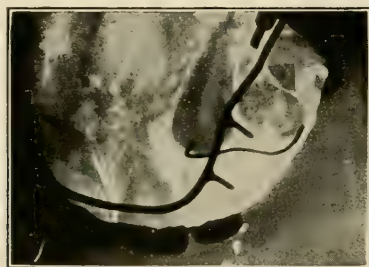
Same as Figs. 150 and 151 after removal of the temporary cuspid. The wire hooked over the cuspid was thought to be placed over the mesial prominence until the radiograph was made. (See Fig. 459.)
